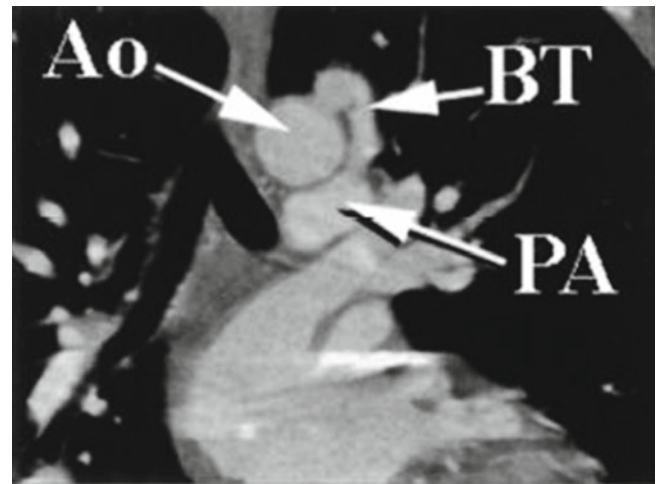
A 64-slice CT angiogram coronal slice of a patient with a Rastelli-type surgical repair of D-transposition of the great arteries with a double-outlet right ventricle. (a) Patent left ventricle (LV) to aorta
